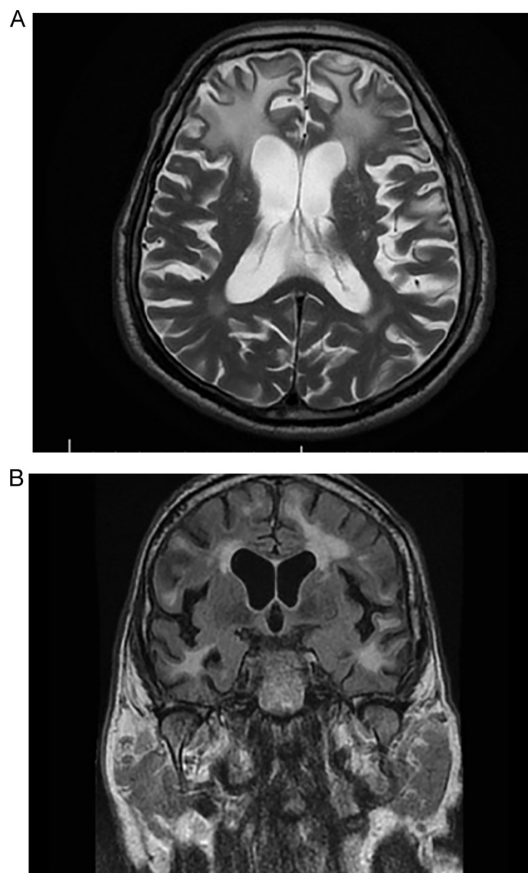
(A) Brain MRI on the second day of hospitalization of case no. 2 (male; age, 76 years) revealed native axial T2 hyperintense plaques without diffusion restriction and bilateral distribution in subcortical frontal and temporal white matter. (B) Brain MRI on the second day of hospitalization of case no. 2 revealed native axial fluid-attenuated inversion recovery hyperintense plaques without diffusion restriction and bilateral distribution in subcortical frontal and temporal white matter.
